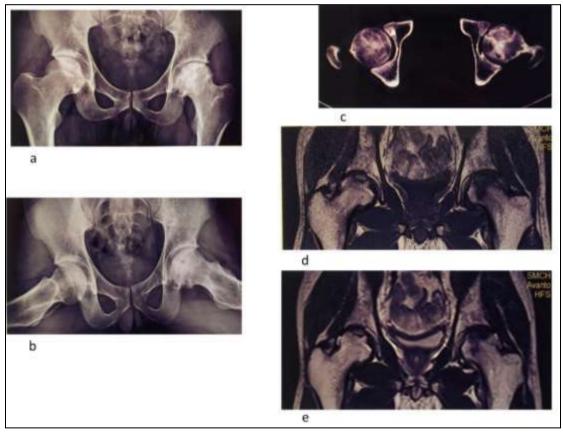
Osteonecrosis of hip. X Ray (a and b), CT(c) MRI T1 Coronal (d), T2 Coronal (e).
